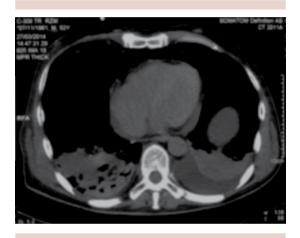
Chest computed tomography scan showing pleural effusions and consolidation areas.
